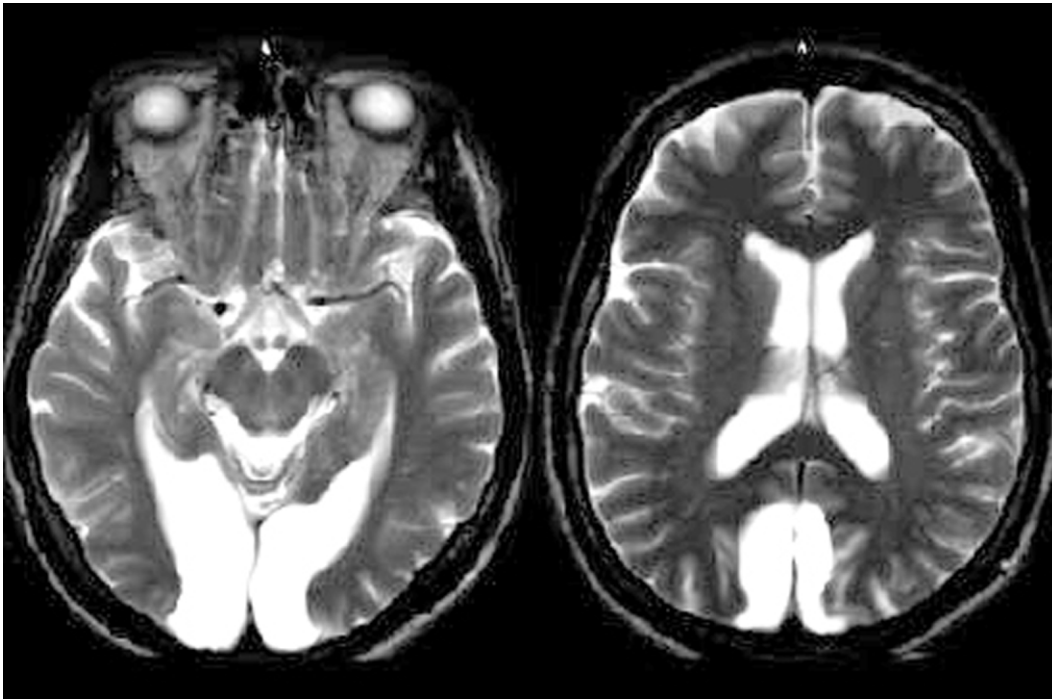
Modified from (Hamilton et al., 2000). T2-weighted brain magnetic resonance imaging (MRI) of early blind woman with sudden onset of alexia for Braille. Note the large, bilateral occipital stroke in distribution of bilateral posterior cerebral arteries.
